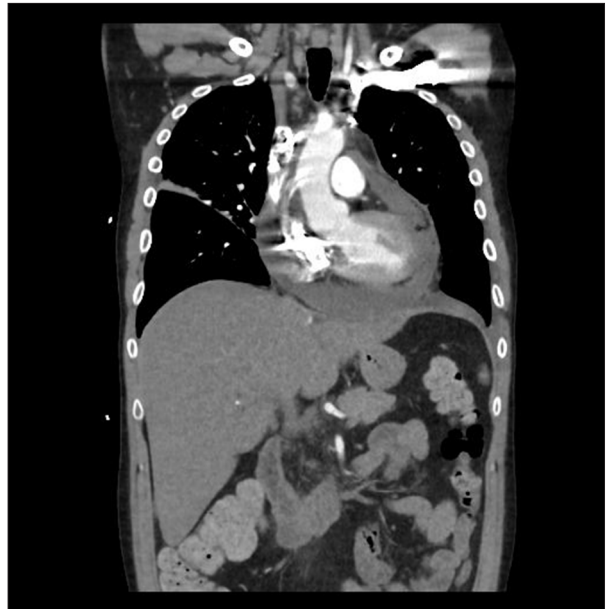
CT scan showing large pericardial effusion with pockets of air within the effusion.
